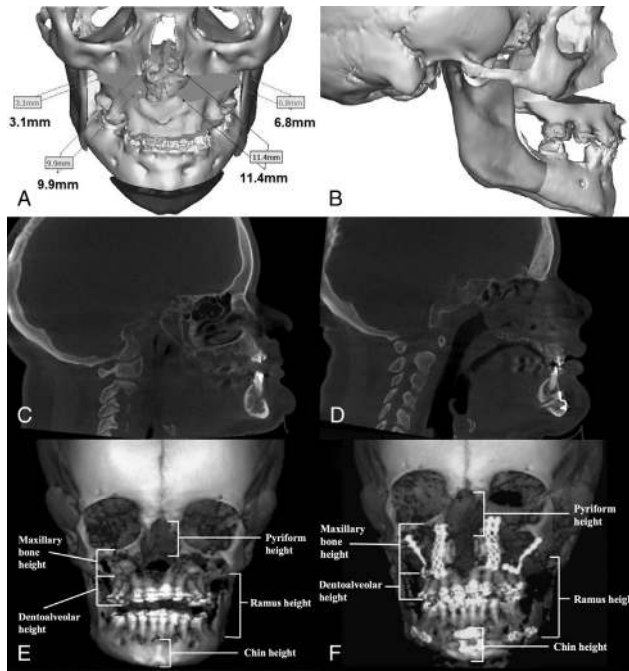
Virtual surgical plan and preoperative versus postoperative CBCT and 3D reconstructions. A) virtual surgical plan bird’s eye view; B) virtual surgical plan lateral view; C) preoperative lateral CBCT demonstrating severely limited maxillary height and projection; D) postoperative lateral CBCT demonstrating improved maxillary and mandibular dimensions; F) preoperative 3D reconstruction anterior view; G) postoperative 3D reconstruction anterior view.
